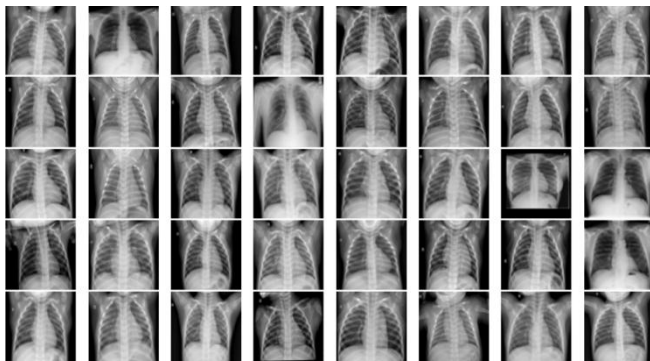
Feature extraction in inception v3 from chest x-ray
